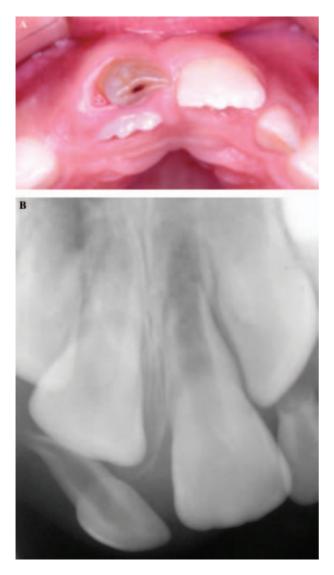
(A) Ectopic eruption of the maxillary right permanent central incisor with retention of the dark discolored primary predecessor. (B) Radiograph showing failure of root resorption of the primary incisor.
